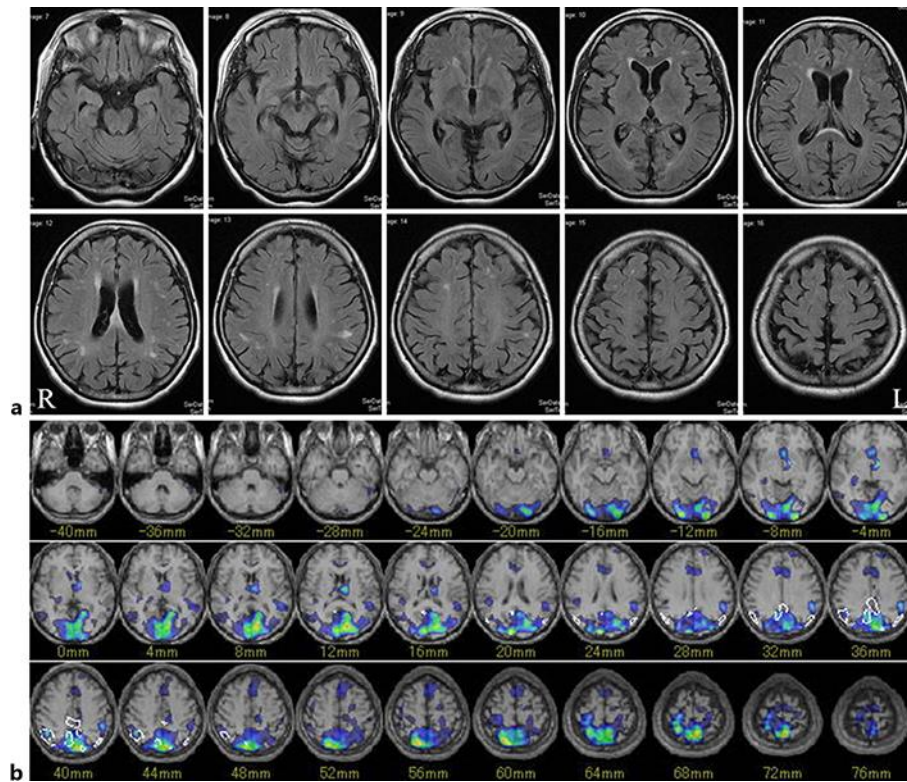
a Brain magnetic resonance images (fluid-attenuated inversion recovery) on day 329. Slightly high signal intensities are to be seen in the periventricular white matter, centrum semiovale, subcortical white matter of the left supramarginal gyrus, and corpus callosum, in addition to mild but global atrophy of the brain. b ^{99m}Tc -ethyl cysteinyl dimer-single-photon emission computed tomography on day 329 (Z score map). Reduced blood flow was observed in the bilateral parietal lobes.
